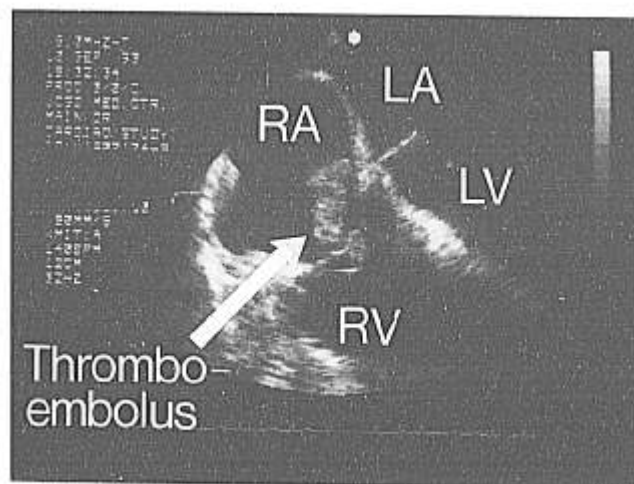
Transesophageal echocardiographic image (four-chamber view of heart) demonstrating thromboembolus (arrow) extending from the right atrium (RA) through the tricuspid valve into the right ventricle (RV). LA = left atrium; LV = left ventricle. One-centimeter intervals are indicated at the right margin of the screen.
